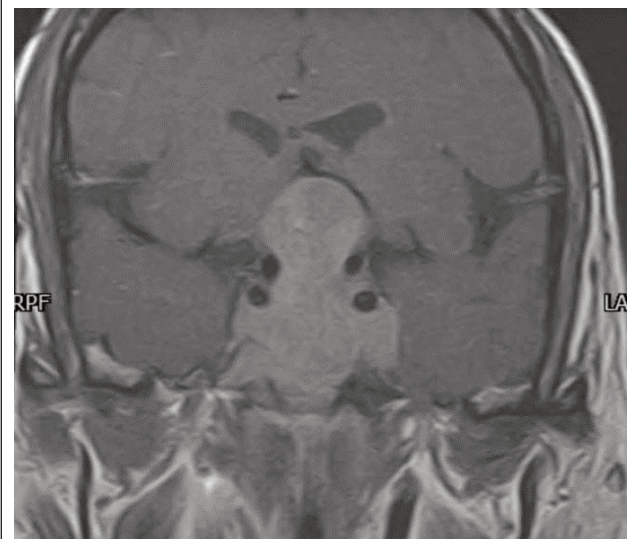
MRI brain, coronal section, delayed image T1 post-contrast sequence, of a 58 years old male, showing a giant contrast enhancing sellar and suprasellar lesion, which is displacing the floor of the 3rd ventricle, and is partially encasing both the internal carotid arteries.
